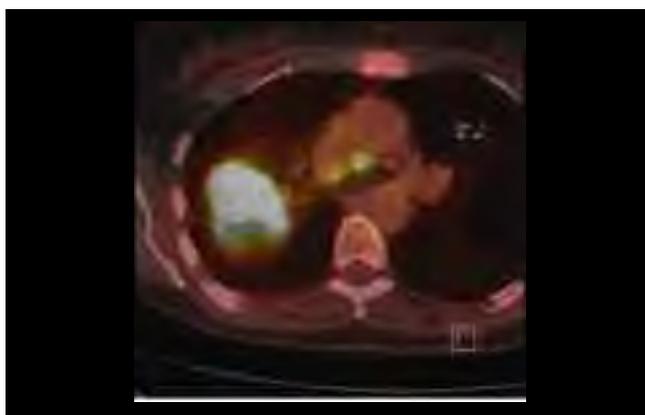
PET CT image showing intense ⁵FDG uptake in a right upper lobe non-small cell carcinoma (a), and pre-tracheal lymph node (b).
